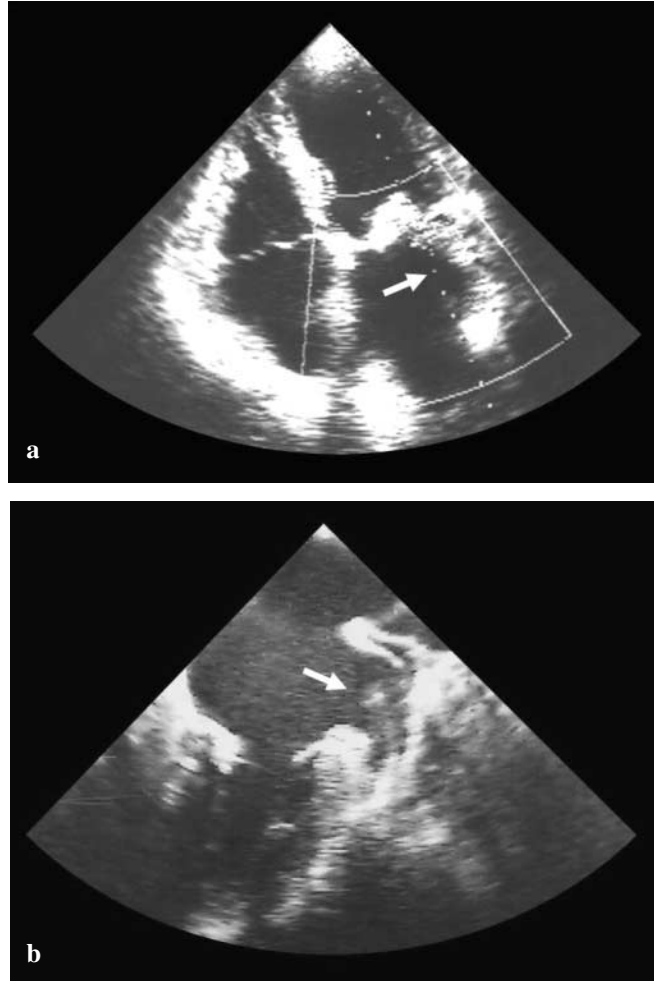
Transthoracic echocardiography view evidencing a moderate regurgitation in left atrium (*white arrow*). b Transoesophageal echocardiography view highlighting a thrombus in the left atrium (*white arrow*)
